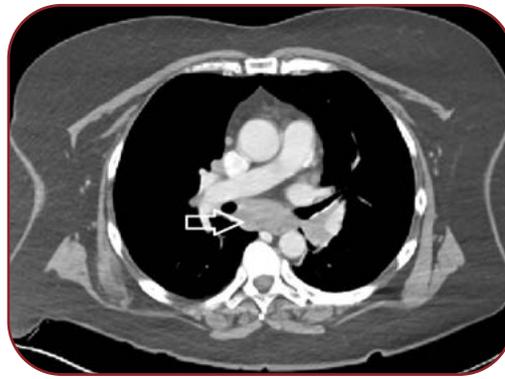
Chest computed tomography showing lymphadenopathy (white arrow)
